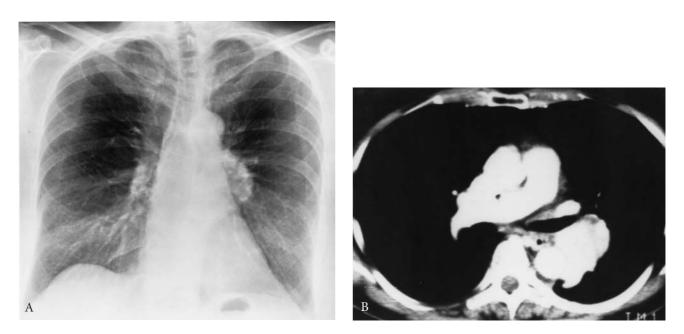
Typical carcinoid tumor. A, Posteroanterior chest radiograph demonstrates a left hilar mass. B, Computed tomography scan with contrast enhancement reveals intense enhancement of the carcinoid tumor in the left lower lobe bronchus.
